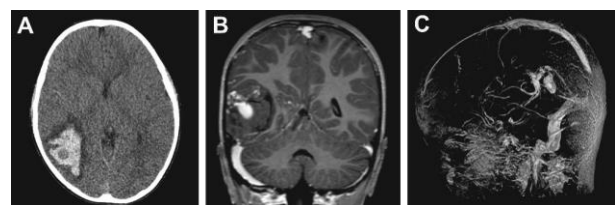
Atypical bleeding case; a- Axial CT, b- Coronal contrasted MRI, c- It is seen in 3D angio window that bleeding is suppressed, and the presence of contrasted vascular anomaly is preserved.
